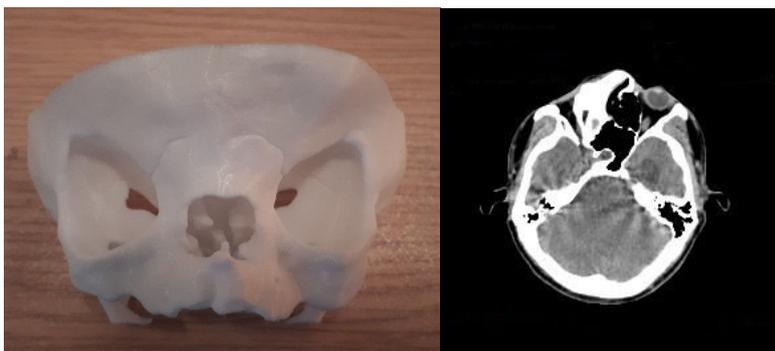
CT and 3D model of orbital anomaly, craniostenosis
